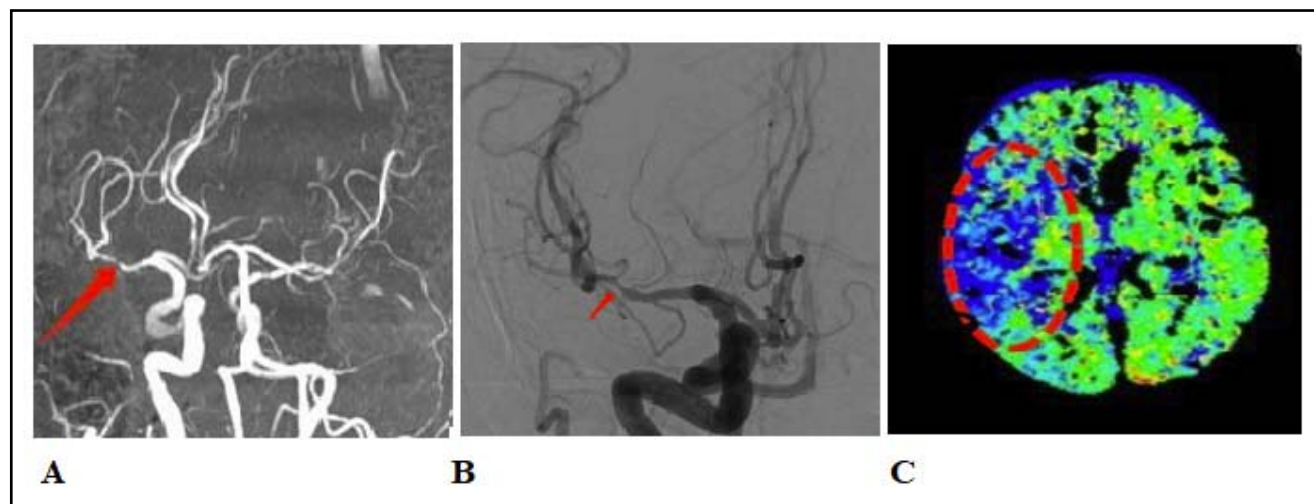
A,B: Magnetic resonance angiography and digital subtraction angiography showed severe lumen stenosis in the M1 segment of the terminal right internal carotid artery (red arrows). C: Cerebral perfusion imaging under Computed tomography revealed a large ischemic penumbra surrounding the infarct (red, dotted circles).
